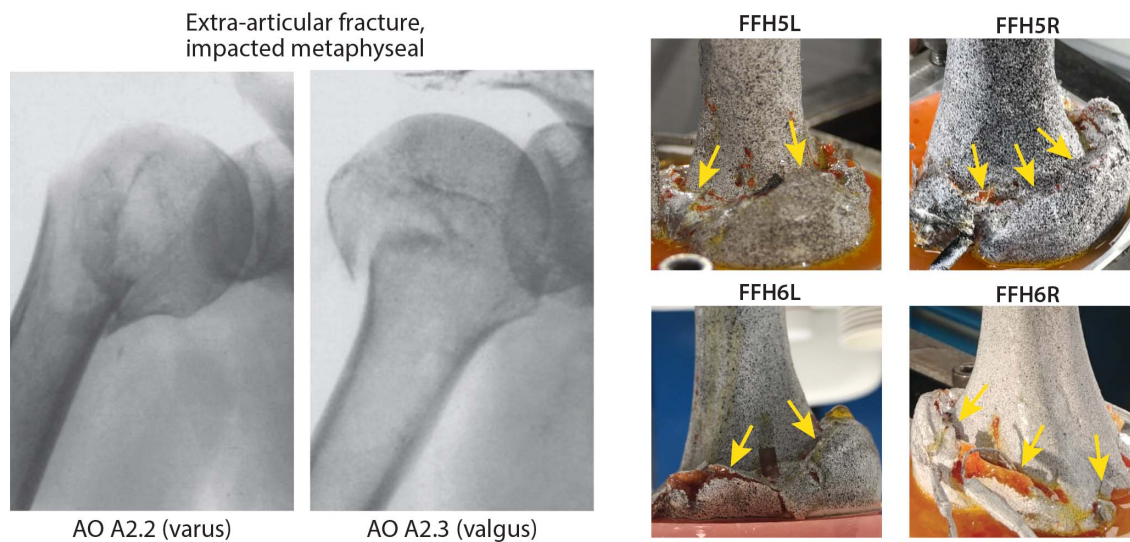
Upper: Fractured humeri showing fracture at their surgical neck, and matching X-rays images (taken from [30]). Lower: Force vs. highest strains measured closest to the fracture location for FFH5R & L and FFH6R. Yield point was defined as the intersection of dashed line (95% of the linear slope) with the force-strain curve. FFH3R & L and FFH4R & L force-strain curves (from [8]) appear in gray.
